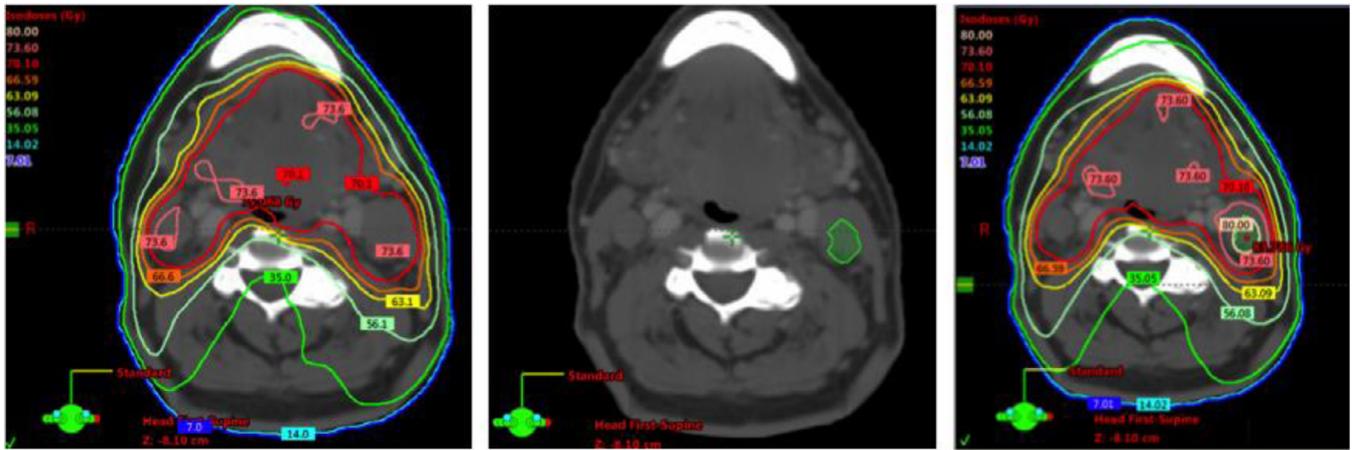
Patient with a cT4N2 HPV+ squamous cell carcinoma of base of tongue was treated with definitive chemoRT on an institutional prospective clinical trial randomizing patients to receive RT boost to areas of poor perfusion or restricted diffusion in multiparametric MRI. (A) Initial RT plan (B) Low BV (poor perfusion) area of tumor spatially identified on pre- and mid-treatment DCE-MRI (C) Adaptive replan to treat the low blood volume tumor subvolume in to left neck to 80Gy (86Gy EQD2).
